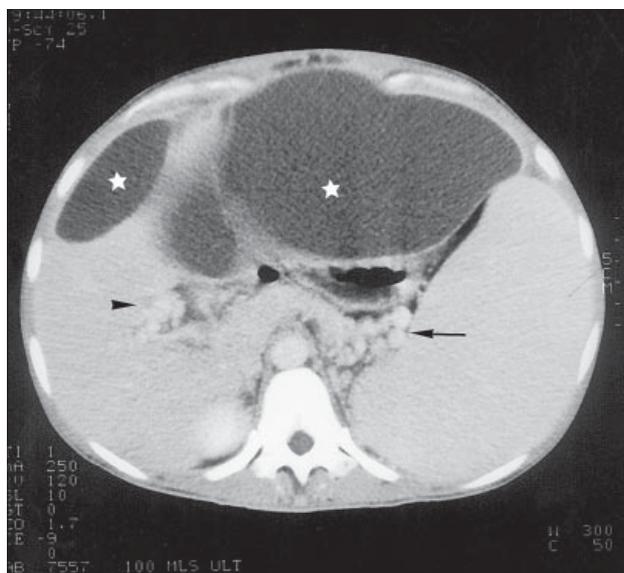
Enhanced computed tomography scan of the pelvis showing loculated collections of fluid (★), cavernous transformation of the portal vein (←), and splenic varices (→).
